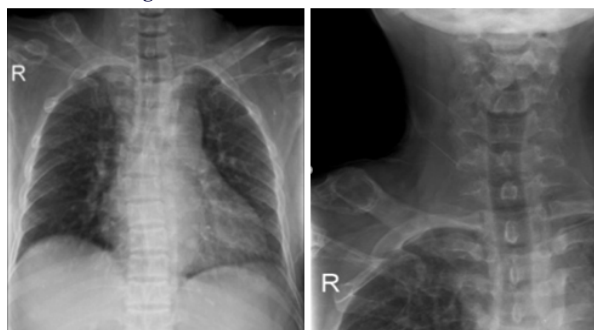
Radiograph Chest AP and Cervical Spine - A.P. view (8 months later)
